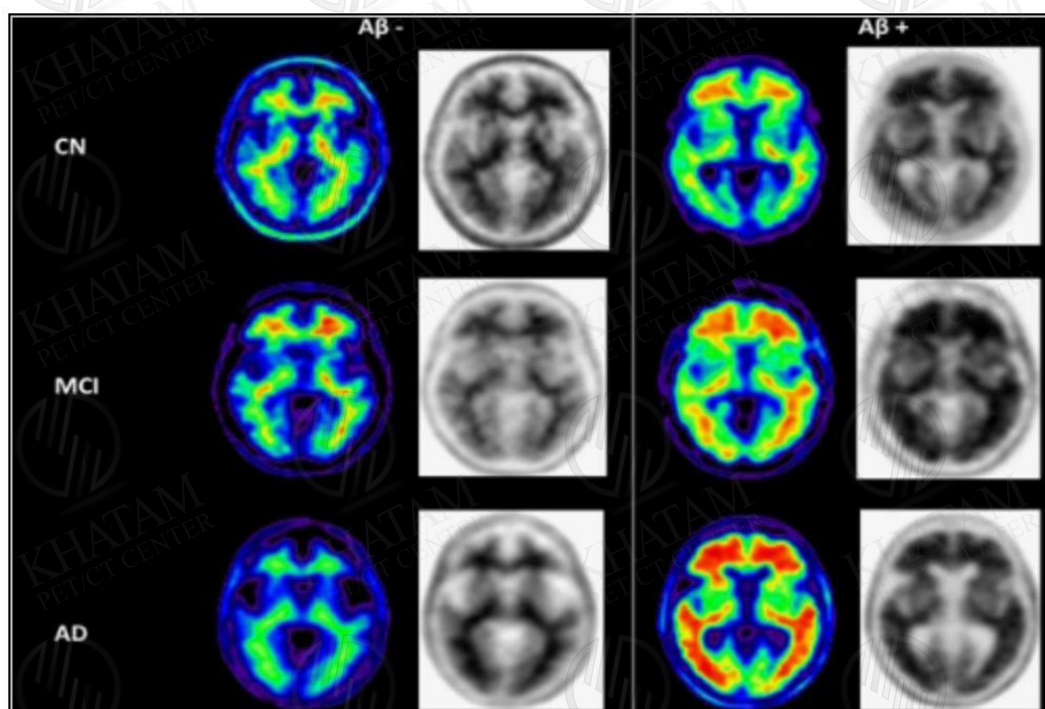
Example images of A β - and A β + subjects clinically classified as cognitively normal (CN), MCI, and AD. Note the absence of gray matter uptake and the difference in average cortical SUVR (standard uptake values relative to the cerebellum) in the A β - vs A β + classified scans.
